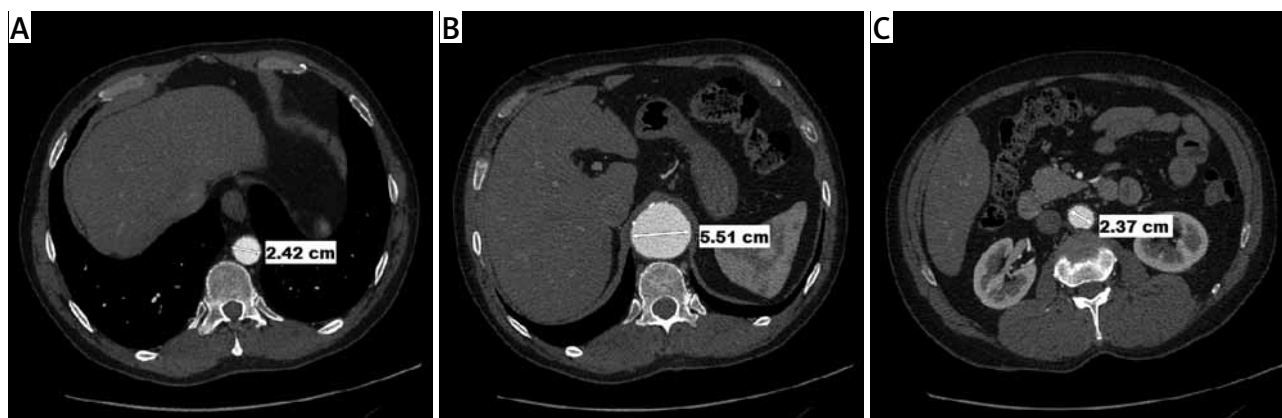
Preoperative imaging of the descending aorta in CT angiography. (A) CT scan with thoracic aorta (24 mm in diameter) above an aneurysm. (B) CT scan at the level of the aneurysm with maximal diameter of 55 mm. (C) CT scan with abdominal aorta below the aneurysm
